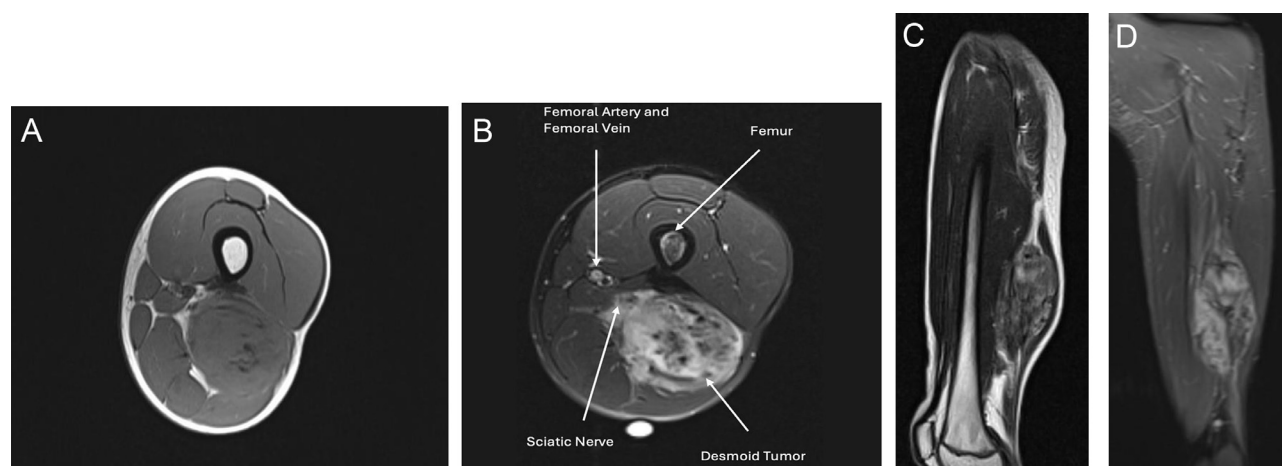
Magnetic Resonance Imaging (MRI) of Left Thigh at mid-thigh level. A: MRI-T1WI Axial; B: MRI-T1WI Axial fat saturation sequence; C: MRI-T1WI sagittal; D: MRI-T1WI sagittal fat saturation sequence. There is a large solitary mass arising from the posterior compartment of the mid-thigh. This mass is isointense to muscle in T1WI, heterogeneously hyperintense in T2WI, and shows no suppression in fat saturation sequence. The mass is partially encasing the sciatic nerve anteriorly. Contrast is not given in this case as the patient has contraindications for contrast agents.
